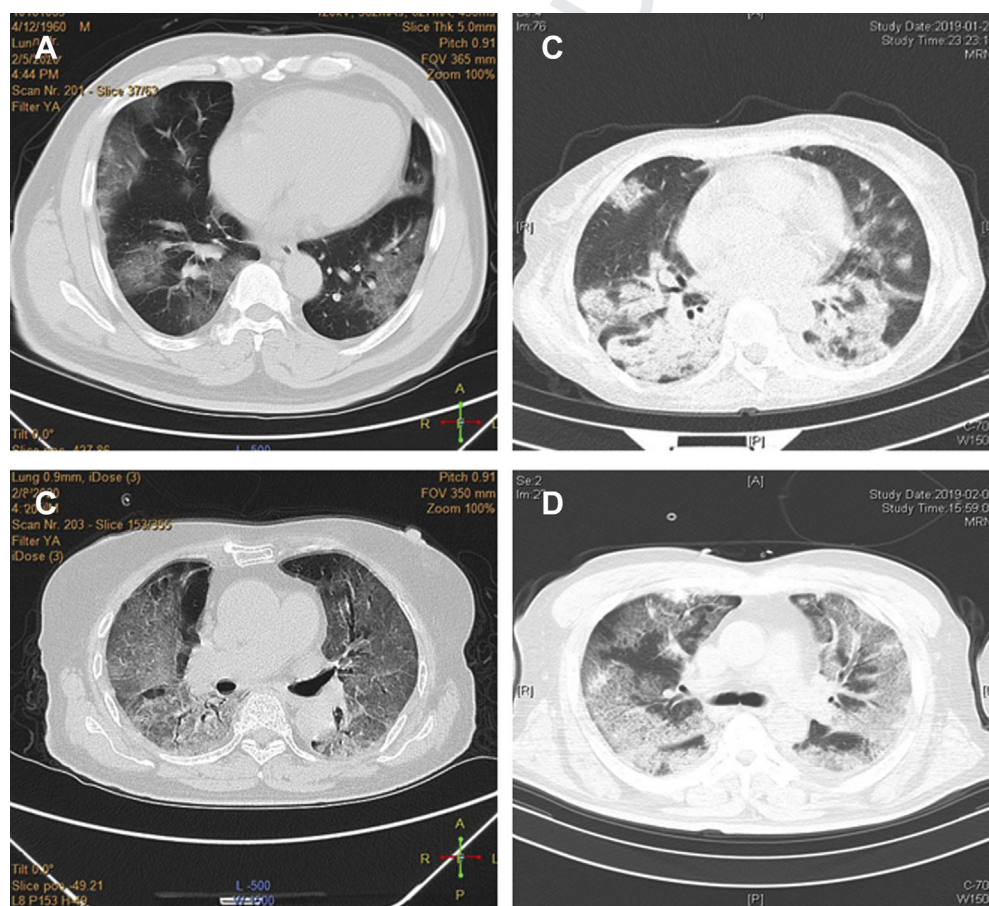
A-D, Imaging characteristics of chest CT scans from patients with coronavirus disease 2019 (COVID-19) and influenza A (H1N1). A, A 60-year-old man with COVID-19 exhibited multiple ground-glass opacities in both lungs. B, A 75-year-old man with COVID-19 exhibited diffuse ground-glass opacities in both lungs. C, A 46-year-old woman with H1N1 exhibited exudation and consolidation distributed with bronchus in multiple lobes and segments. D, A 66-year-old man with H1N1 exhibited ground-glass opacities with little exudation and consolidation distributed diffusely in both lungs.
